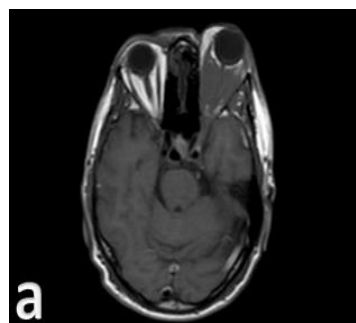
(a&b): A case of 14-year-old boy with painful proptosis: MRI orbit was done, axial T1WI and T2WI images (a&b) respectively show diffuse infiltrative soft tissue orbital mass affecting intraconal, extraconal spaces, retro bulbar fat and orbital muscles. It measures about 2x2.5x3cm respectively (Ap x Tr x H) respectively. It displayed low SI on T1WI and mixed SI on T2WI.
